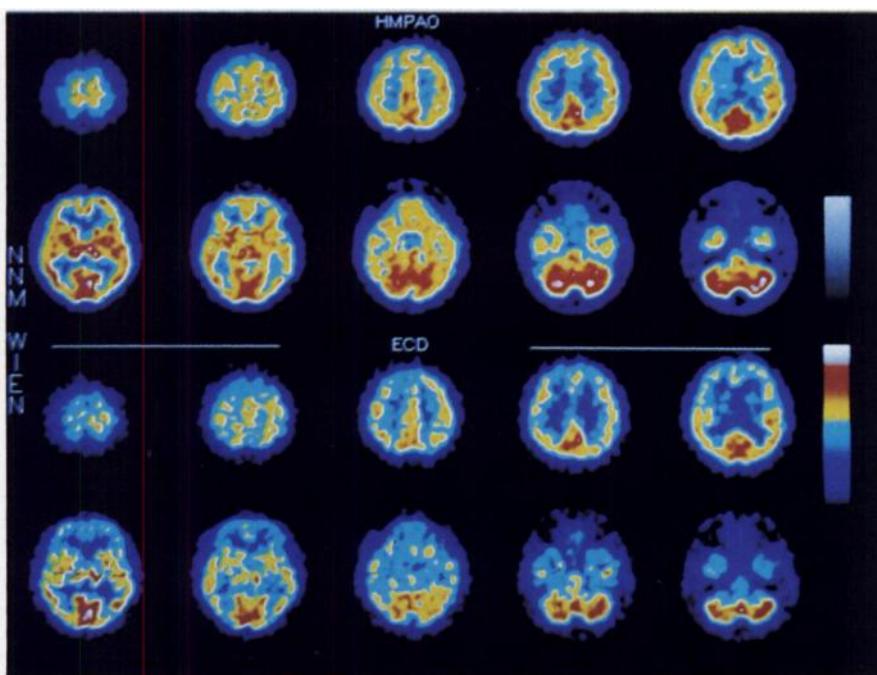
Row 1 + 2: ^{99m}Tc -HMPAO SPECT study (Patient 6); Row 3 + 4: ^{99m}Tc -ECD SPECT study of the same subject. Both studies are scaled to their own maximum. In contrast to the ^{99m}Tc -HMPAO SPECT study, ^{99m}Tc -ECD demonstrates relatively high tracer uptake in the occipital cortex and comparatively low tracer uptake in the mediotemporal regions, basal ganglia and thalamus, respectively.
